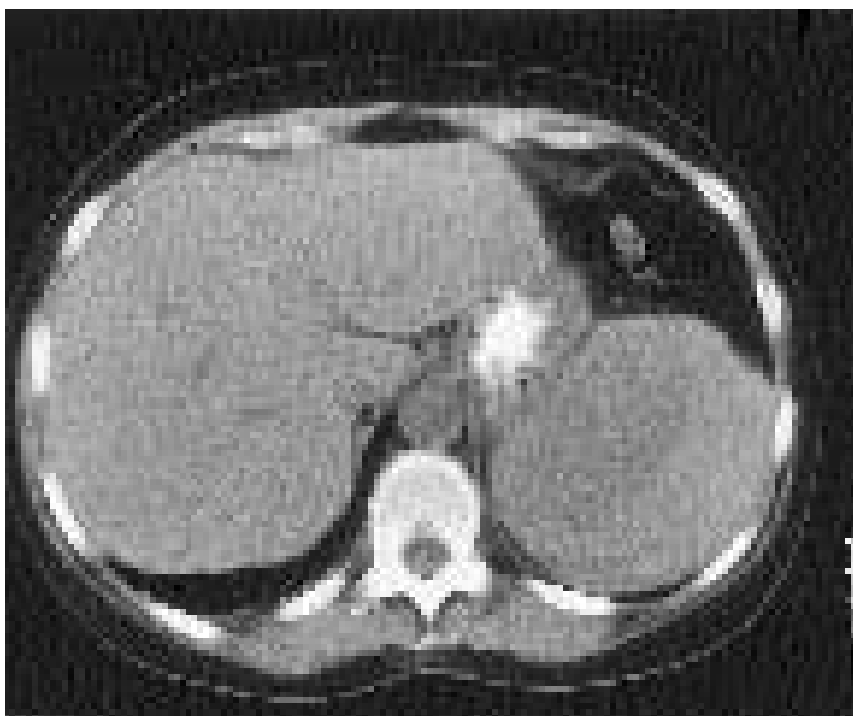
Computed tomography scan on day 5 showing extensive subcapsular haematoma.
